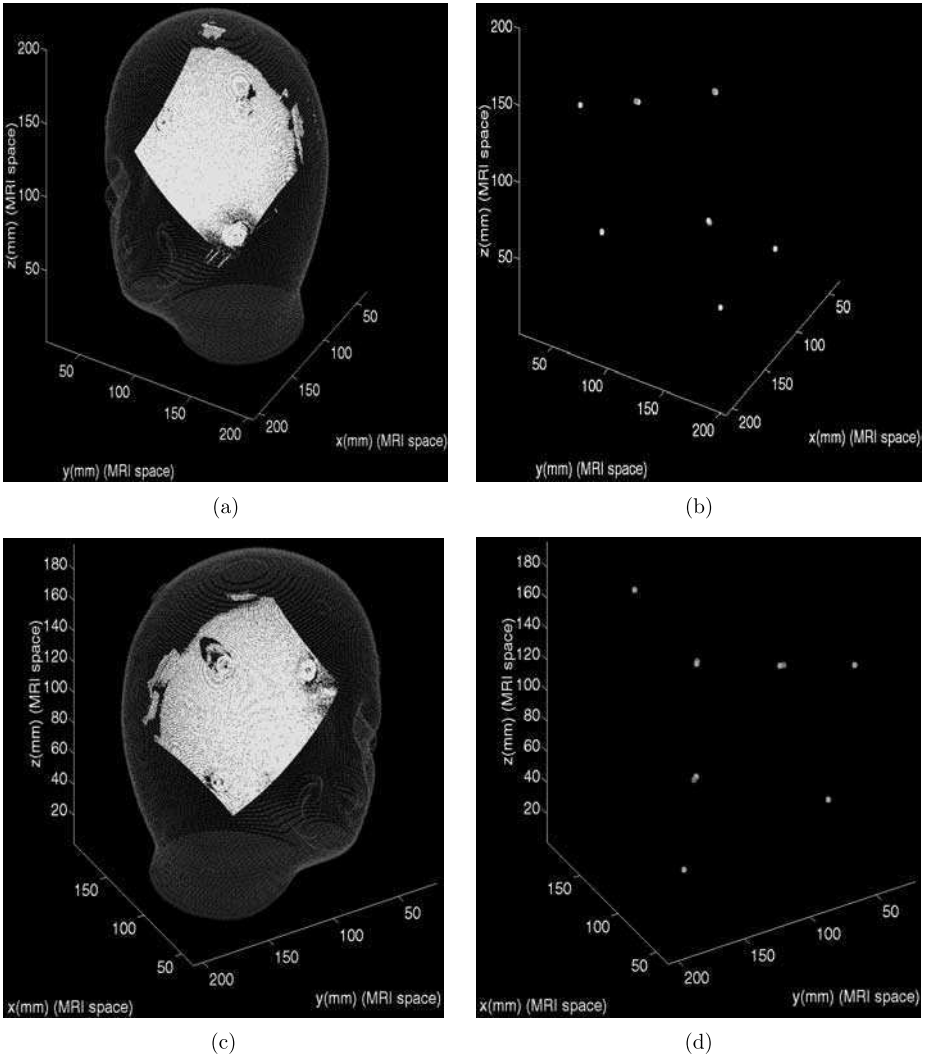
Range-CT transformation results (trial 1): (a)–(b) left side: (a) range data transformed to CT space overlaid on CT data; (b) CT (gray) and transformed range space (white) fiducials; (c)–(d) right side: (c) transformed right side range data overlaid on CT data; (d) CT space and transformed range space fiducials.
